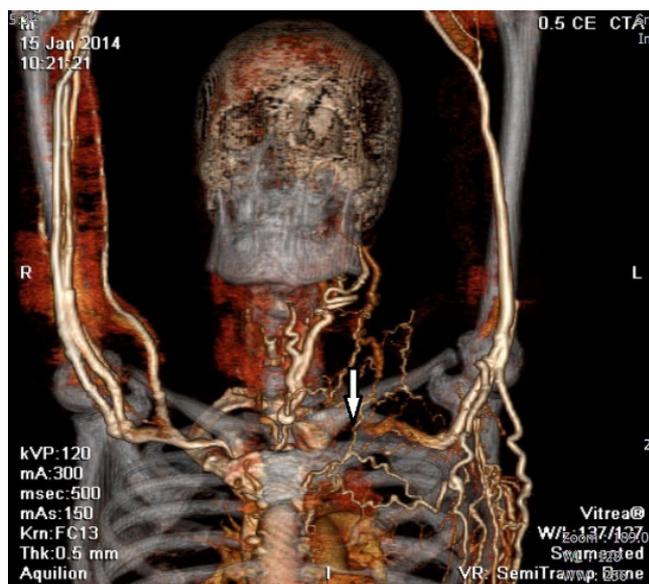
Direct computed tomography venography 3D Volume Rendered image of a 52 year-old male demonstrates left brachiocephalic vein thrombosis (arrow). Much collateral veins are noted at left hemithorax.
